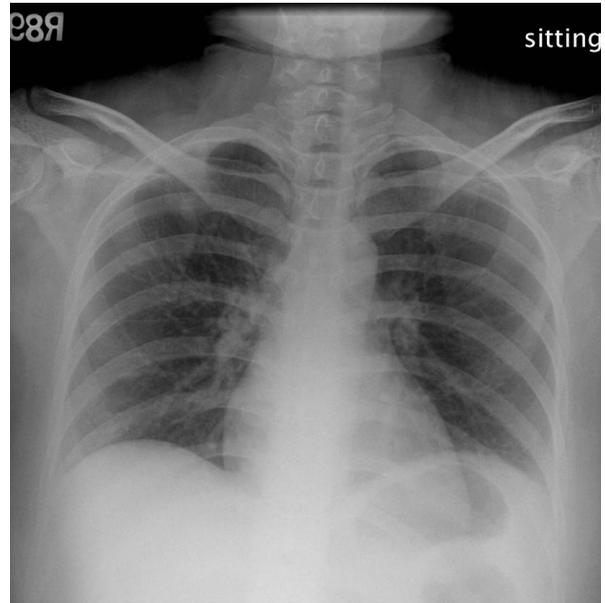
Chest radiography showing a nodule with adjacent infiltrate in the right upper lung zone
